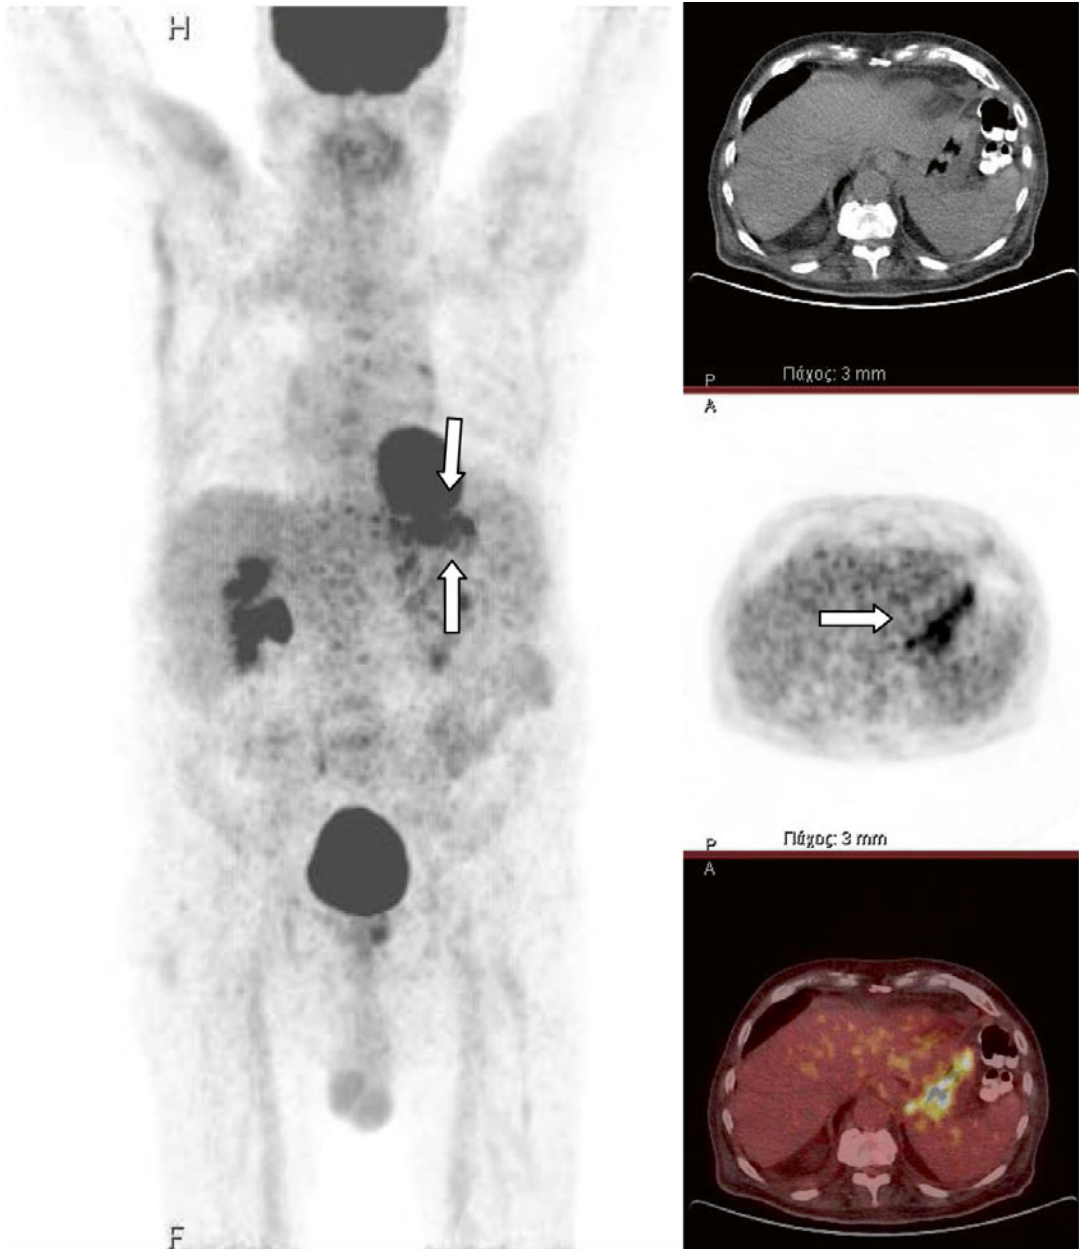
An 85-year-old male with MALT lymphoma. Initial staging evaluation with PET/CT (coronal PET images (left) and transverse CT, PET, and fused images
